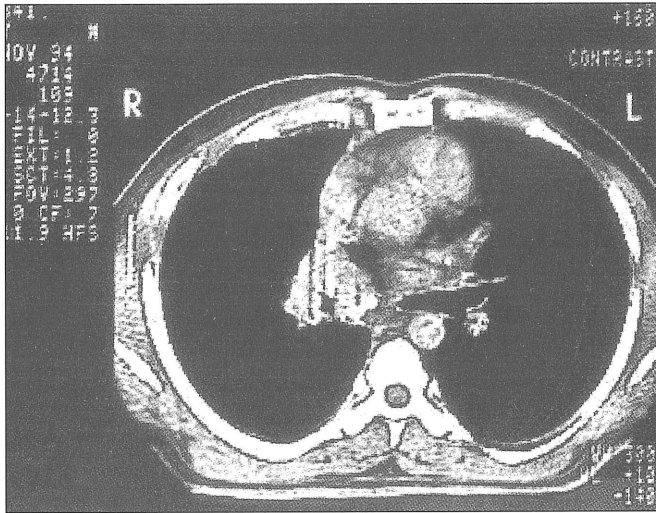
Chest CT scan in November 1994. A 4.5 cm mass lesion surrounding the right main bronchus
